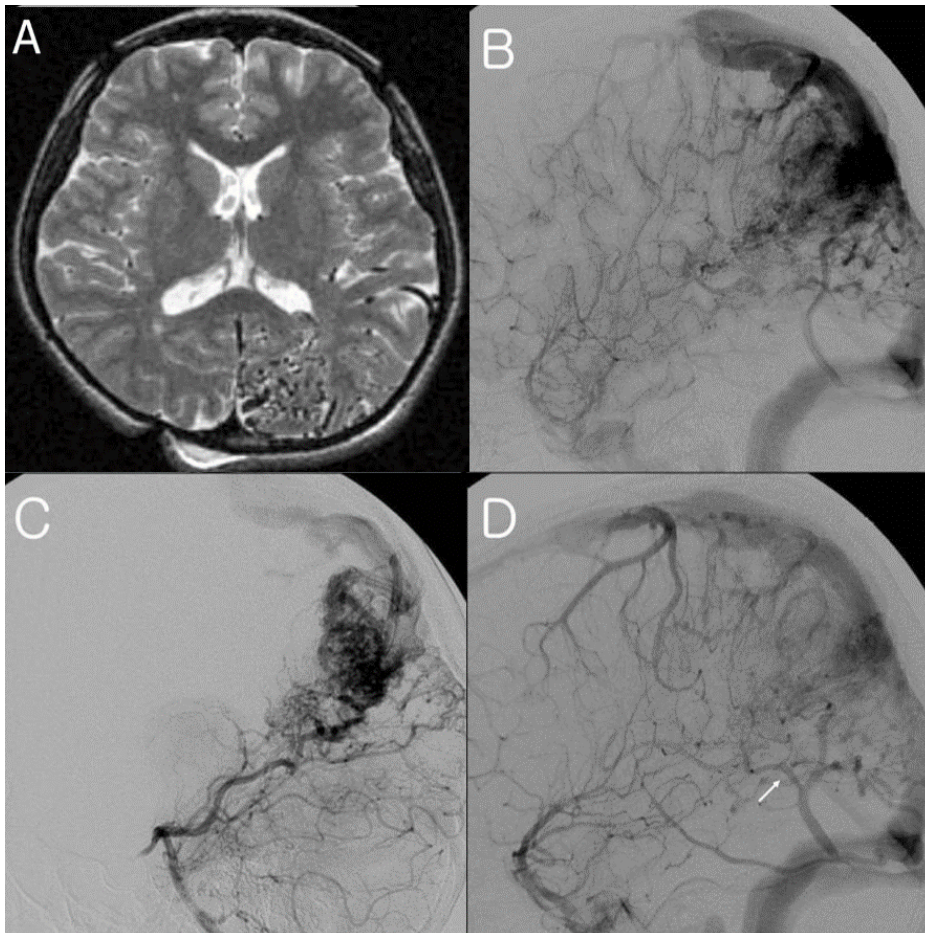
Magnetic resonance imaging (MRI) revealed a high-flow large AVM in the left parieto-occipital lobe. (Fig. 1A) The AVM had a nidus with a diameter greater than 5 cm at its greatest dimension. The transfemoral carotid angiogram (TFCA) revealed multiple, tortuous feeding arteries and dilated draining veins that showed the high shunt flow of an AVM.
